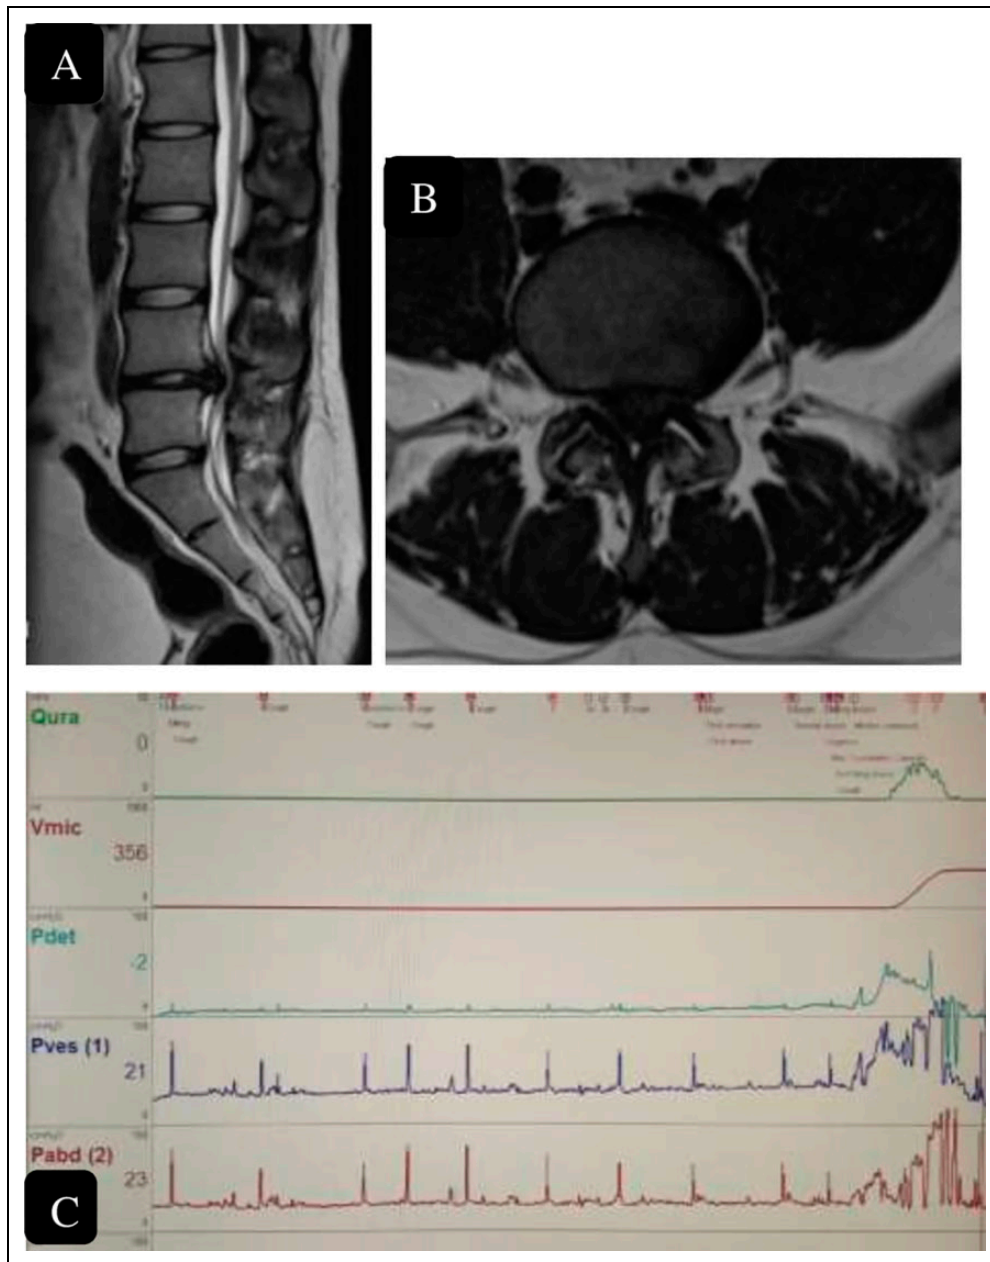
31 year old female presented with sudden onset bilateral radiculopathy and perianal numbness and difficulty in voiding micturition. Magnetic resonance imaging revealed L4-5 lumbar disc herniation (A, B). UDS revealed a hypocontractile bladder (C) there is raise in intravesical pressure reflecting raise in intra-abdominal pressure resulting in strained voiding.
